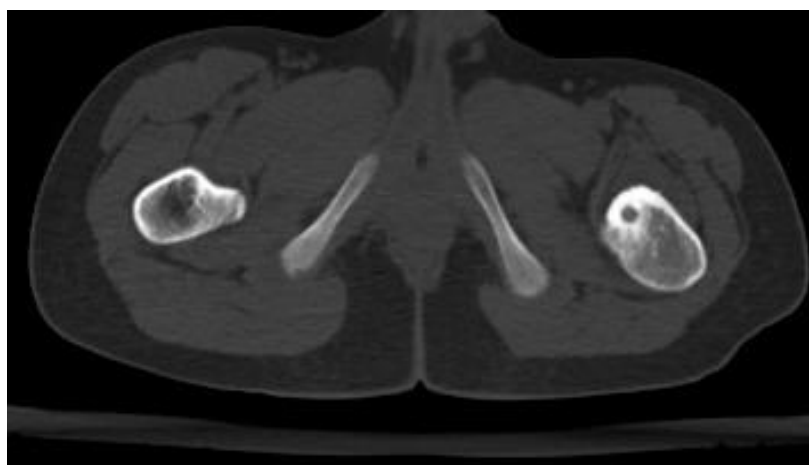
Case 2 Male, 14 years old, osteoid osteoma of proximal femur, 2014-9-2, preoperative CT axial position
